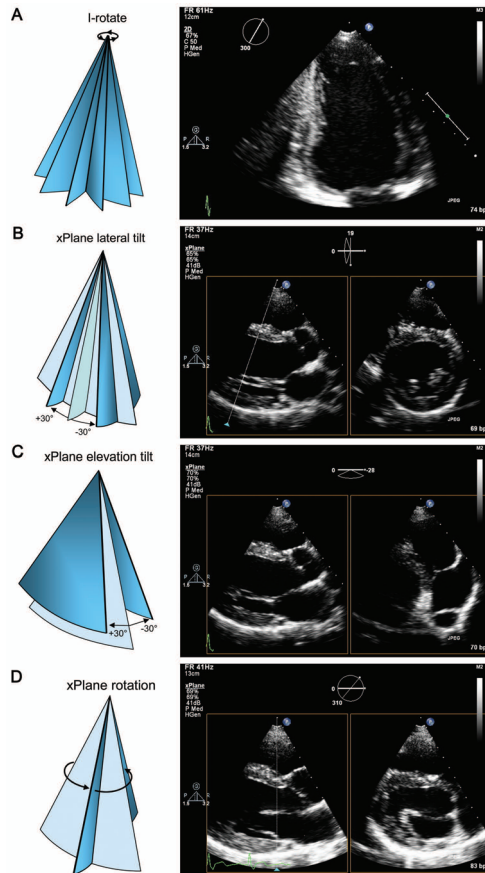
Simultaneous multiplane imaging mode. A. iRotate: a two-chamber view is obtained by rotation of 60° (to 300°) from a standard four-chamber view (defined as 0° or 360°). The degree of rotation is displayed in the upper left-hand corner of the screen. B. xPlane with lateral tilt: from a standard parasternal long-axis view (primary image or reference plane) an orthogonal short-axis view at the chordal–papillary muscle level can be obtained by a lateral tilt of $+10^\circ$. C. xPlane with elevation tilt: from the same view a right ventricular inflow view can be obtained by an elevation tilt of -28° . D. xPlane with rotation: from the same view an unorthodox short-axis view of the mitral valve by a rotation of $+50^\circ$.
